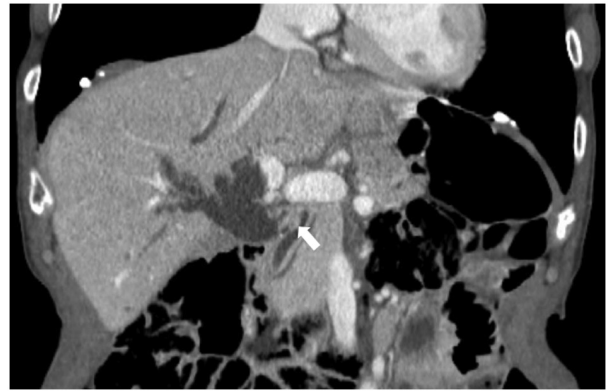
Image acquired from multi detector-row computed tomography revealing dilation of the biliary tree and a 10-mm enhanced nodule (arrow) in the distal bile duct.
